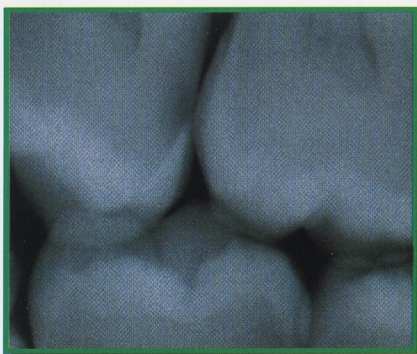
Radiograph of lesion.
